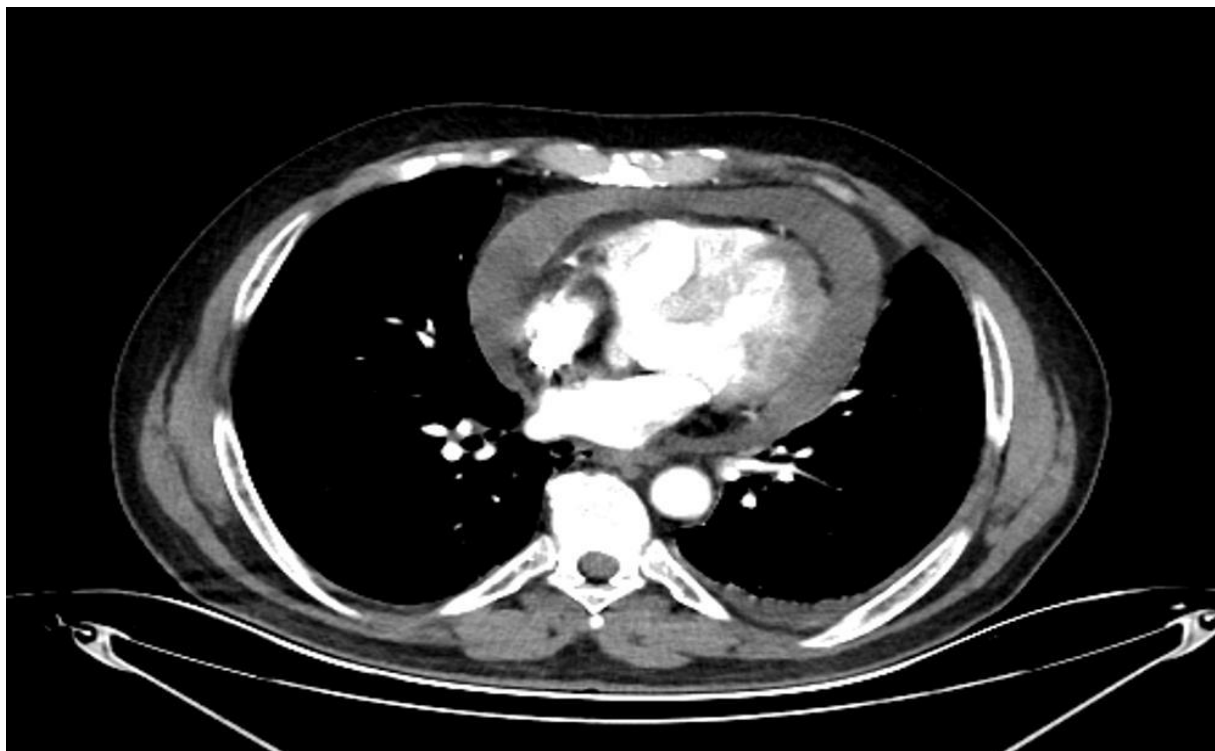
Thoracic Computed Tomography.
